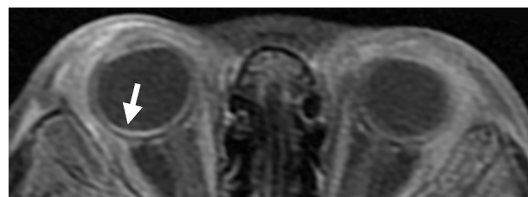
Axial fat-suppressed gadolinium-enhanced T1-weighted sequence showing thin linear enhancement along the right posterior choroid, presumed diffuse choroidal hemangiomas with background Sturge-Weber syndrome (white arrow).
